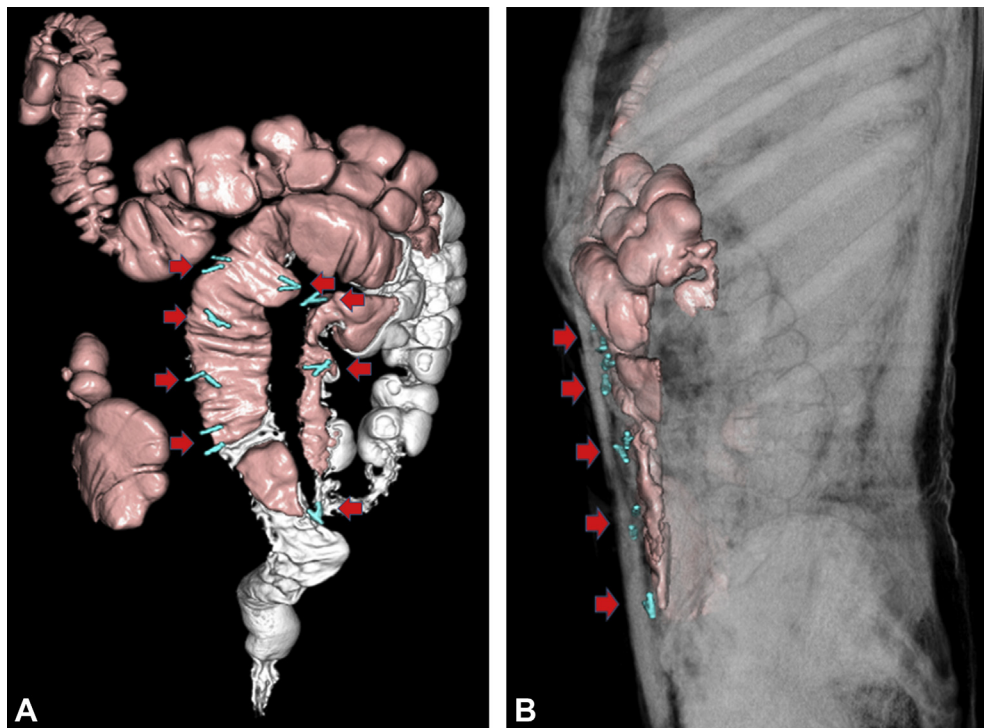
CT colonography showing the fixation site of the sigmoid colon to the abdominal wall. A, Front view; B, lateral view.
